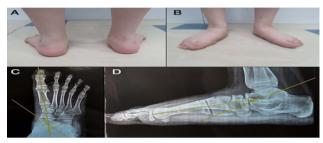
(A): Clinical photo of a patient with the bilateral spasmodic valgus foot from behind showing hindfoot valgus; (B): Clinical photo of a patient with the bilateral spasmodic valgus foot from the front showing planovalgus feet; (C): Precorrection anteroposterior standing radiograph showed no coalition and increased anteroposterior Meary's angle was 32 degrees; (D): Precorrection lateral radiograph showing C sign, lateral radiographic measurements of the lateral talar's first metatarsal angle was 18 degrees.
